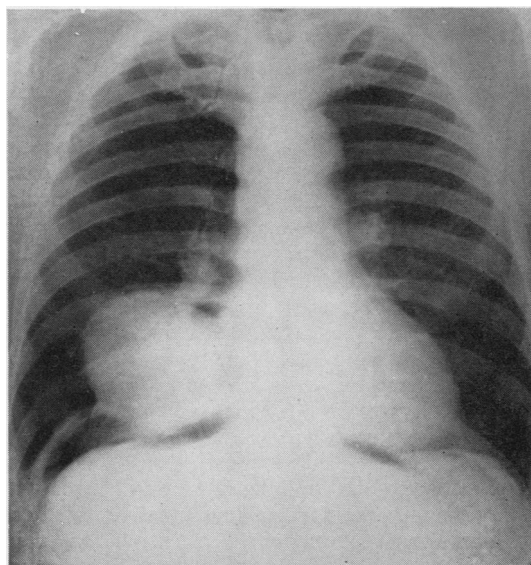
This patient had a normal radiograph four years before and was found to have a pericardial coelomic cyst at thoracotomy.
